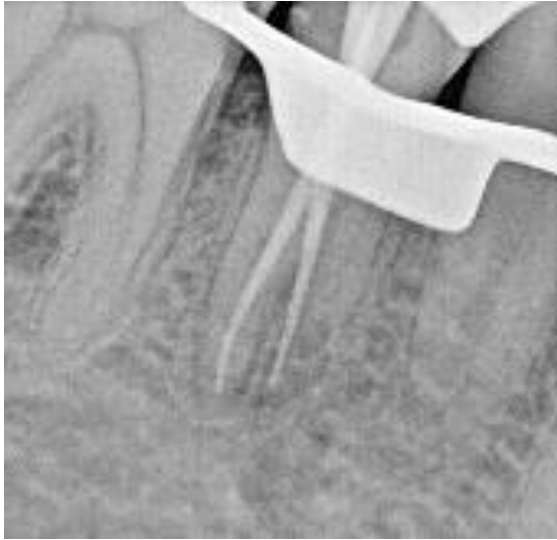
Master cone Radiograph (45).
